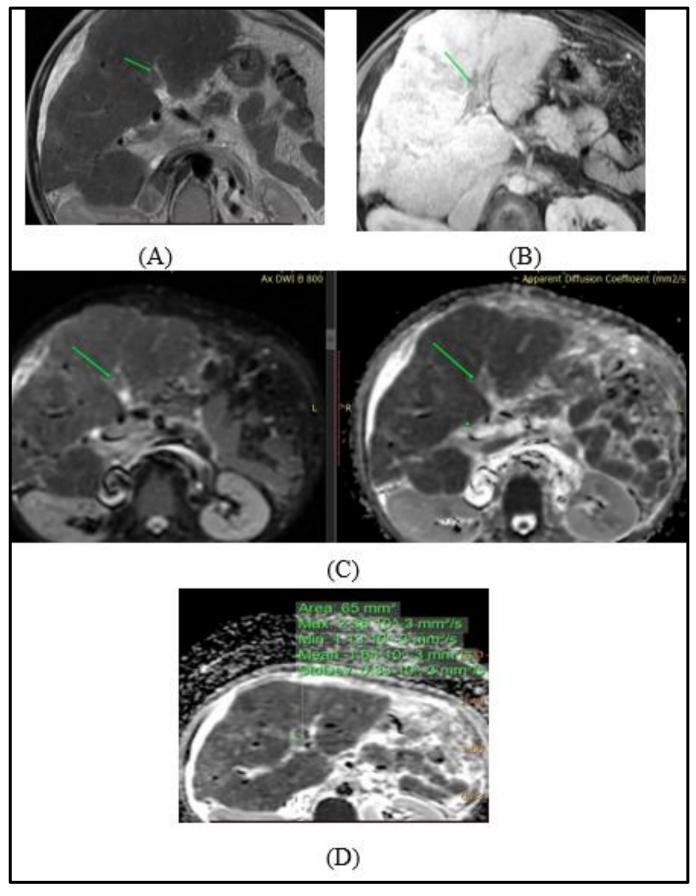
Benign left PVT: [A] axial T2 image shows distended left PV with intraluminal thrombosis showing hypointense signal [orange arrow]. [B] axial post contrast arterial enhancement showing no enhancement [orange arrow]. [C] DWI&ADC map images of PVT showed no diffusion restriction. [D] On ADC, the signal intensities within the thrombus were measured and the value of main PVT was $1.64 \times 10^{-3} \, \mathrm{mm}^2/\mathrm{sec}$.
